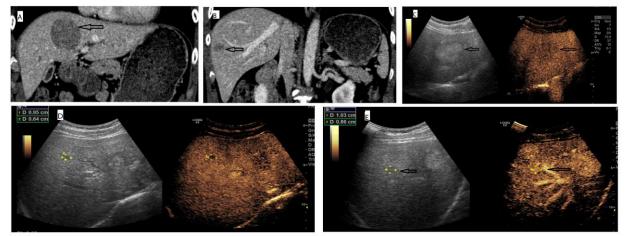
Case 1: The patient was with HCC. In the patient, CECT detected only 2 lesion, while CEUS detected 3 lesions. CECT: Contrast-enhanced computed tomography; CEUS: Contrast-enhanced ultrasound
